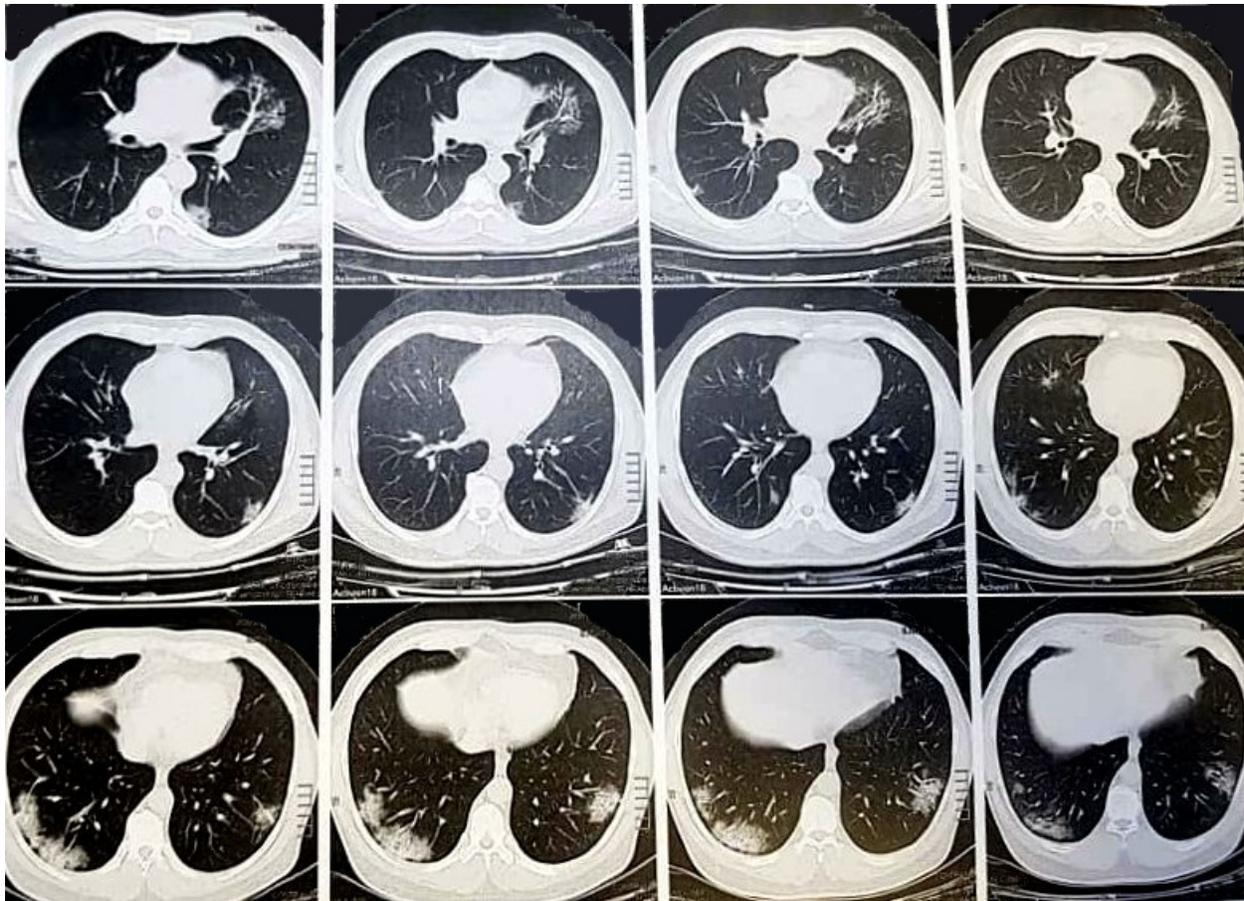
Chest CT scan of case 2 shows patchy peripheral ground glass opacities and consolidations in both lungs
